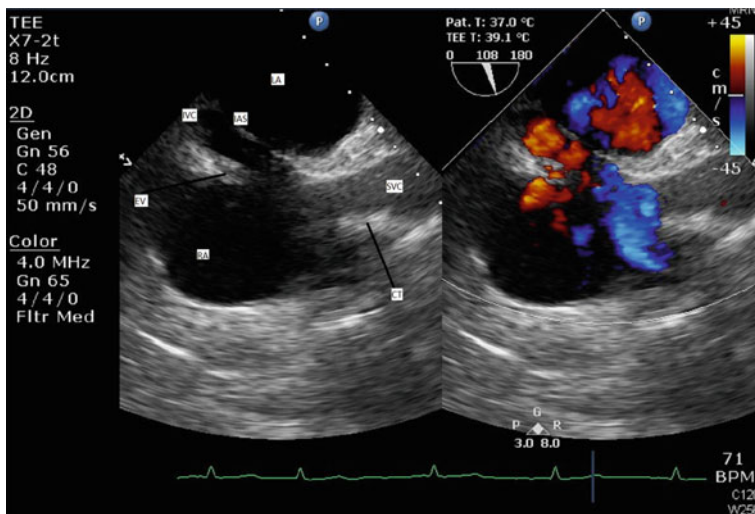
ME Bicaval view showing laminar venous blood flow into both atria. SVC = Superior Vena Cava, IVC = Inferior Vena Cava, LA = Left Atrium, RA = Right Atrium, IAS = Inter Atrial septum, CT = Christa Terminalis and EV = Eustachian Valve
